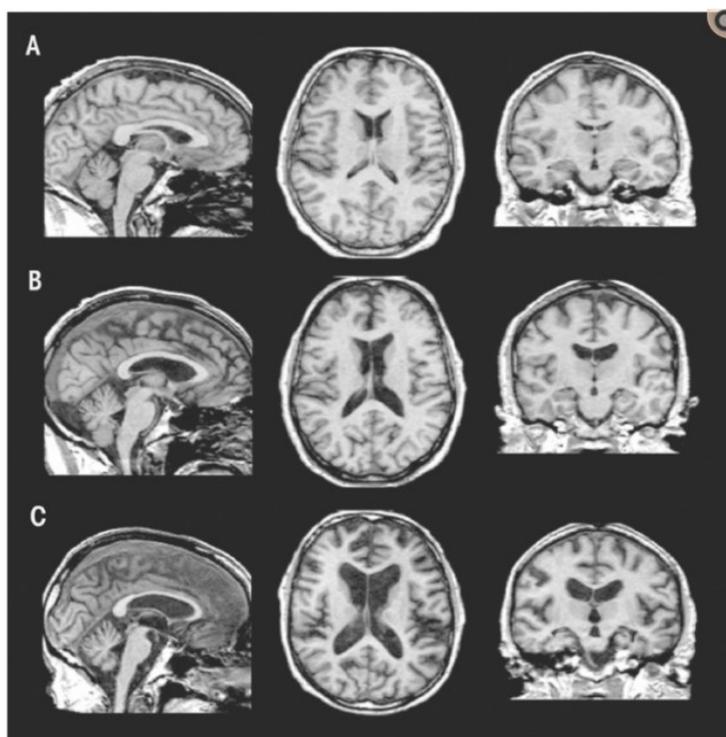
A Comparison of MRIs from control patients (A), uncomplicated alcoholics (B) and Wernicke-Korsakoff Syndrome patients (C). *Note.* An MRI Comparison of control brains, Wernicke-Korsakoff Syndrome brains, and Uncomplicated Alcoholics. Taken from Alcohol's Effect on the Brain. Zahr, 2017.
